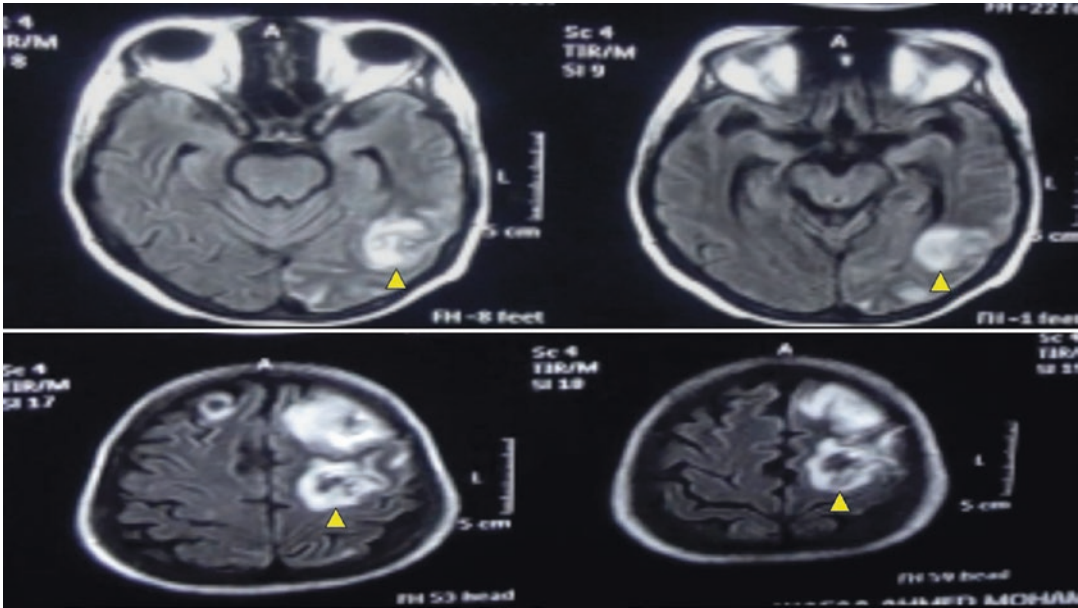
Cranial MRI with IV contrast, T2 weighted, showing an SLE patient whose condition was complicated with subacute bacterial endocarditis (SBE) and multiple
